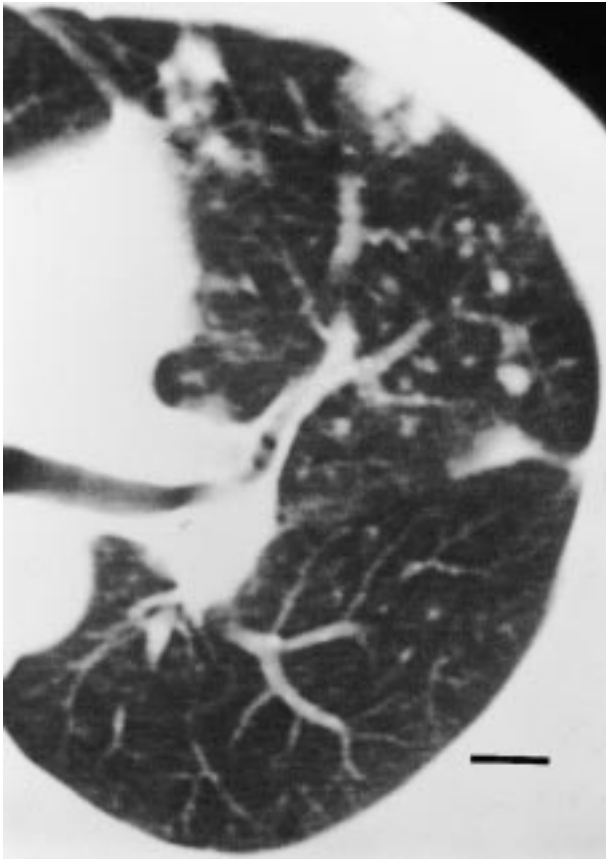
Preoperative chest computed tomography findings of centrilobular nodules and nodules >10 mm. (Internal scale bar=1 cm.)
